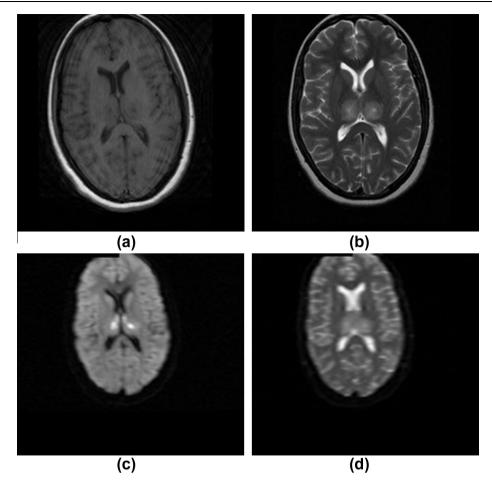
(a) T1 WI showing low SI in both thalami. (b) T2 WI showing high SI in both thalami. (c and d) DWI and ADC map showing free diffusion with high SI in DWI due to T2 shine through and high SI in ADC map denoting vasogenic edema.
